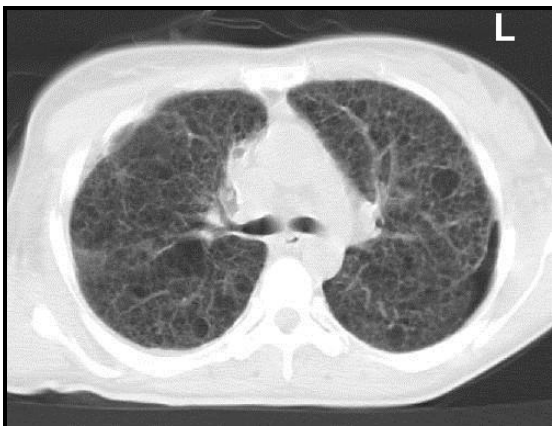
Thorax CT showed multiple parenchymal cysts in lungs.
